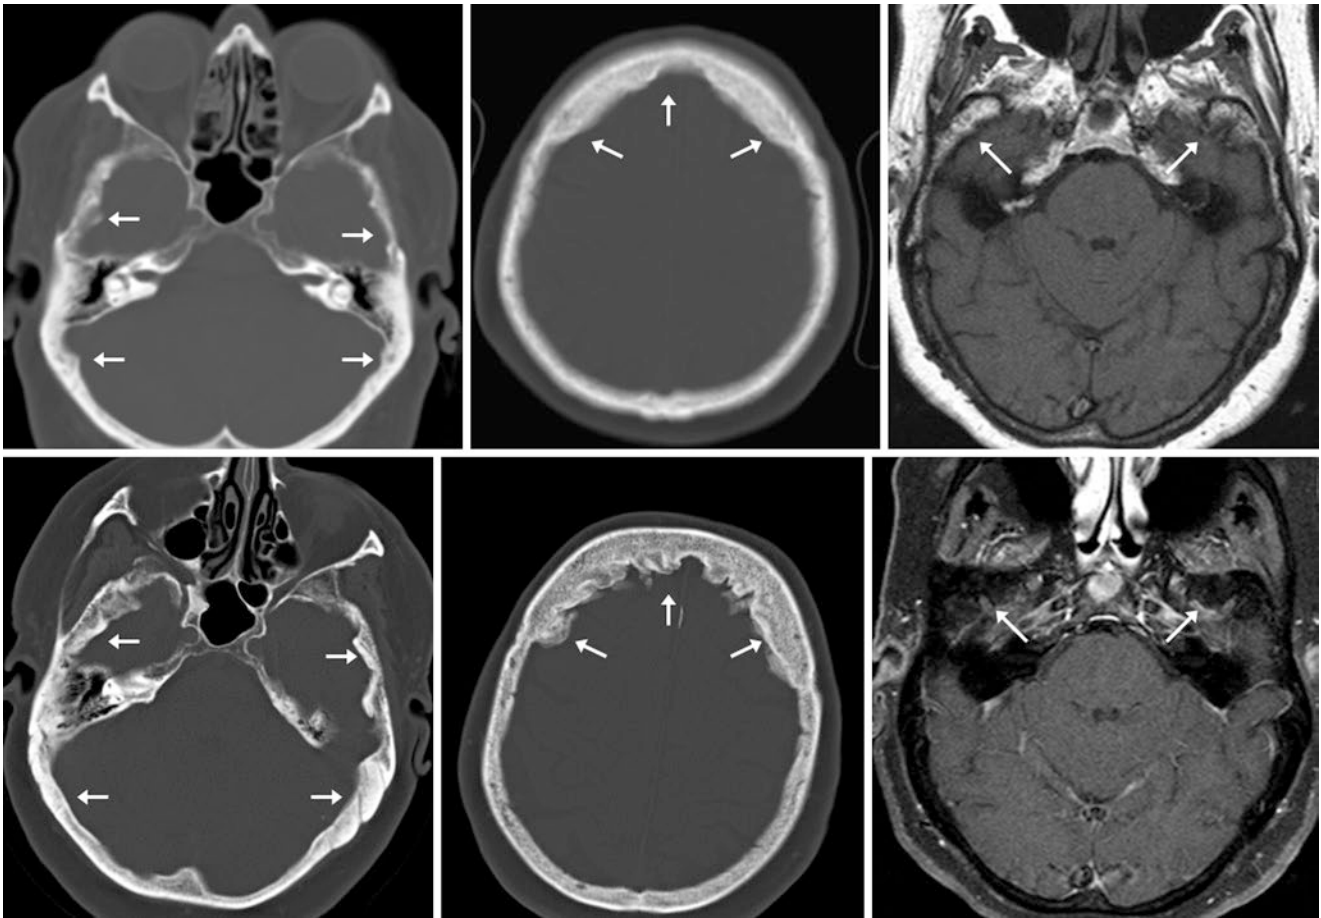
An 80-year-old female with asymptomatic HCD noted on a NECT from 1997 (*top left and middle*). Note temporal bone hyperostosis on a 1.5T noncontrast T1WI MRI (*top right*). The hyperostosis had progressed on NECT 10 years later (*bottom left and middle*). Note suppression of bright fatty marrow on the later T1WI MRI, which utilized FS (*FS, bottom right*)
